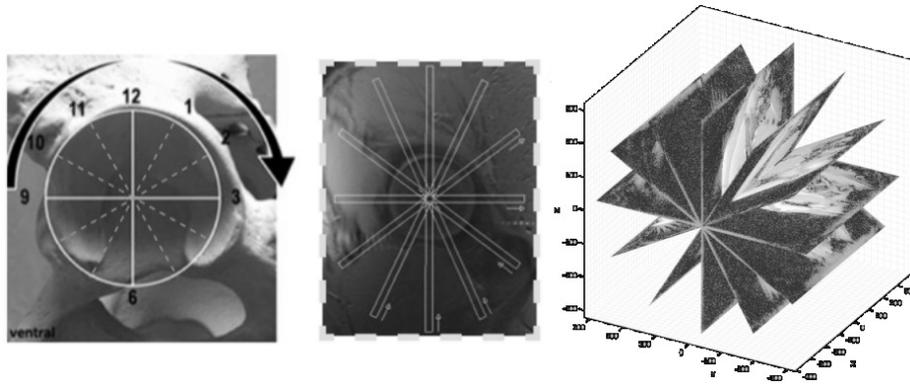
Radial scans orientation(from left to right): i) superimposed over hip socket, ii) superimposed over a 2D MRI scan, iii) visualized in 3D space
